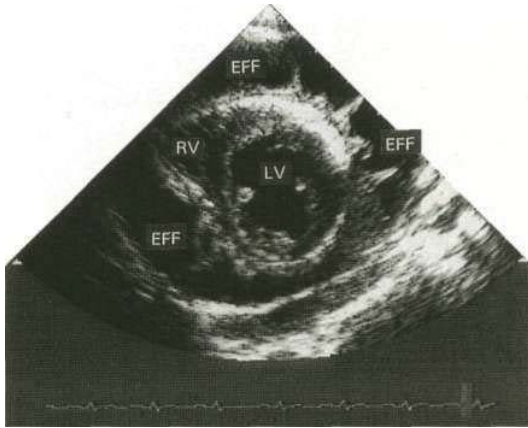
Two-dimensional echocardiogram (short-axis view) from a patient with a large pericardial effusion associated with pulmonary tuberculosis. The exudate is seen between the visceral and parietal layers of the pericardium and would give a false impression of cardiomegaly on a chest X-ray. Note the multiple fibrous strands within the effusion, showing that it is consolidating and will probably lead to constriction of cardiac function. LV, left ventricle; RV, right ventricle; EFF, effusion.
